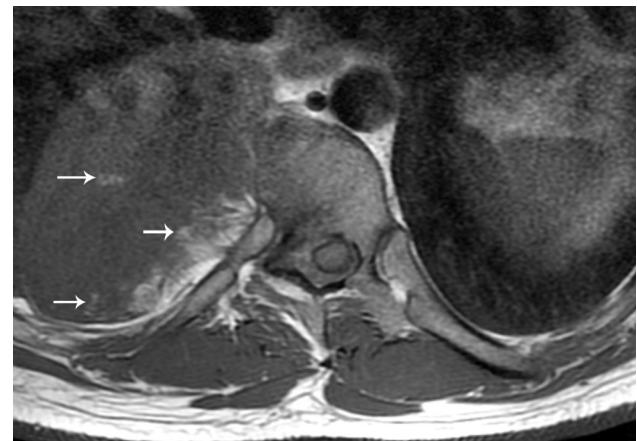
Axial unenhanced T1-weighted magnetic resonance image showed a heterogeneous low-signal intensity tumor with high-signal intensity lipomatous component (arrows).
